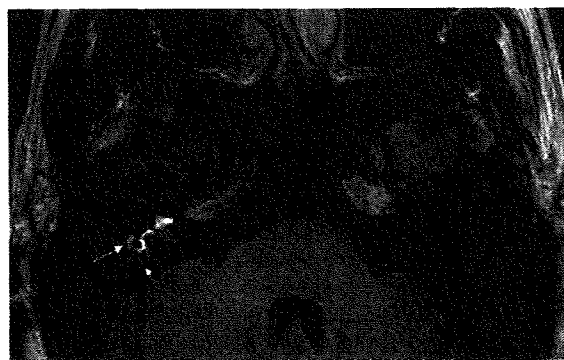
Axial magnetic resonance image. The right inner ear of a 33-year-old man with Ménière's disease. Three-dimensional fluid-attenuated inversion recovery magnetic resonance image taken 1 day after intratympanic injection of Gd shows that the Gd is in the basal and second turns of the cochlea, vestibule, and semicircular canals. The long arrow indicates the horizontal semicircular canal, and the short arrow indicates the posterior semicircular canal.
